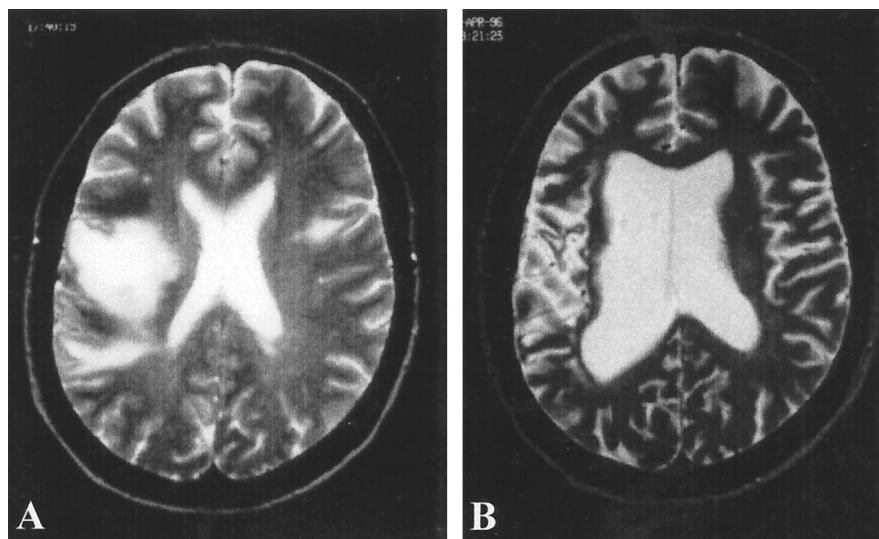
Sequential T2-weighted MRI scans of a non-AIDS-related PML patient with acute lymphocytic leukemia before diagnosis (A) and 200 weeks after diagnosis (B). Despite an aggressive course of cytarabine, some residual scarring in the lesion site was present at 200 weeks.
